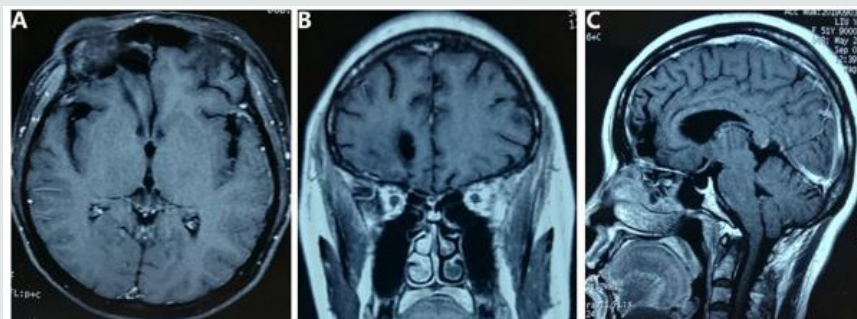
Postoperative MR images.
